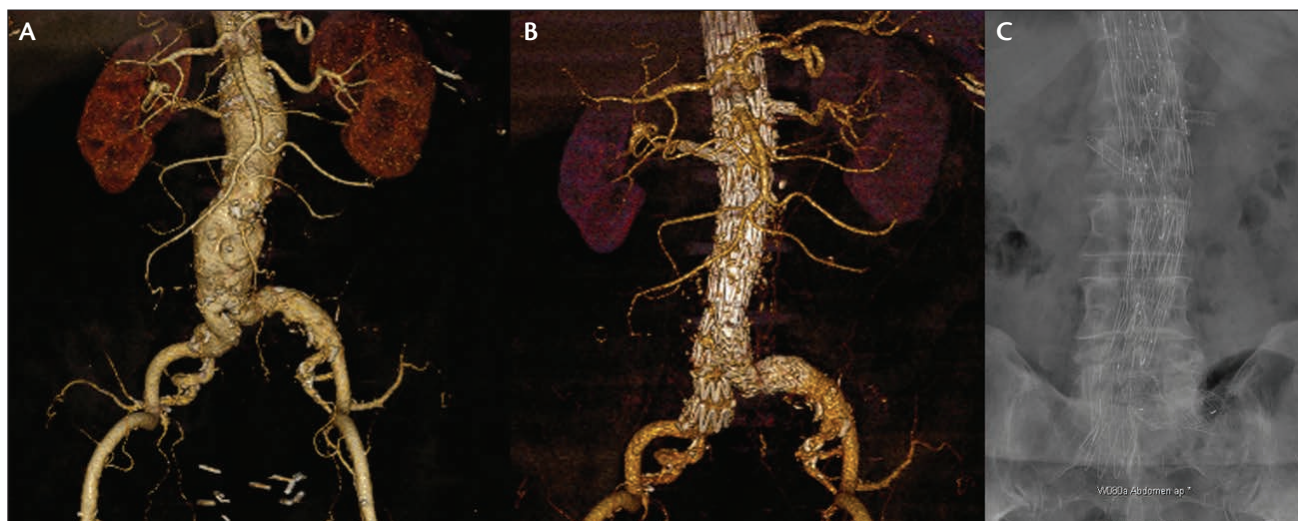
Three-dimensional volume-rendered CT reconstruction of a patient with severe left iliac angulation treated with a combination of a Zenith stent graft body (Cook Medical) and an Excluder (Gore & Associates) iliac limb (A). CTA (B) and x-ray (C) 2 years postoperatively, showing good patency of the graft limb.
